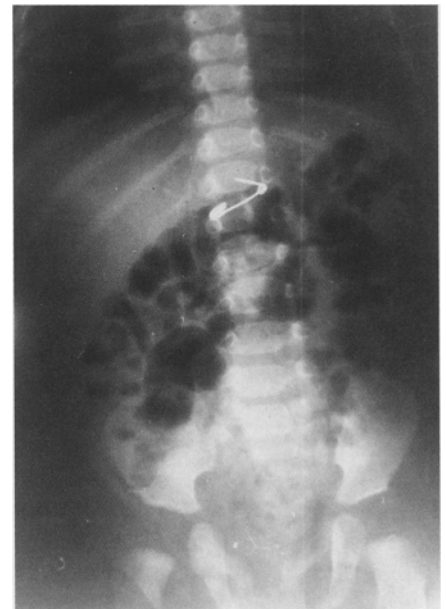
AP radiograph of patient 11 shows wide-open safety pin puncturing posterior wall of duodenum
